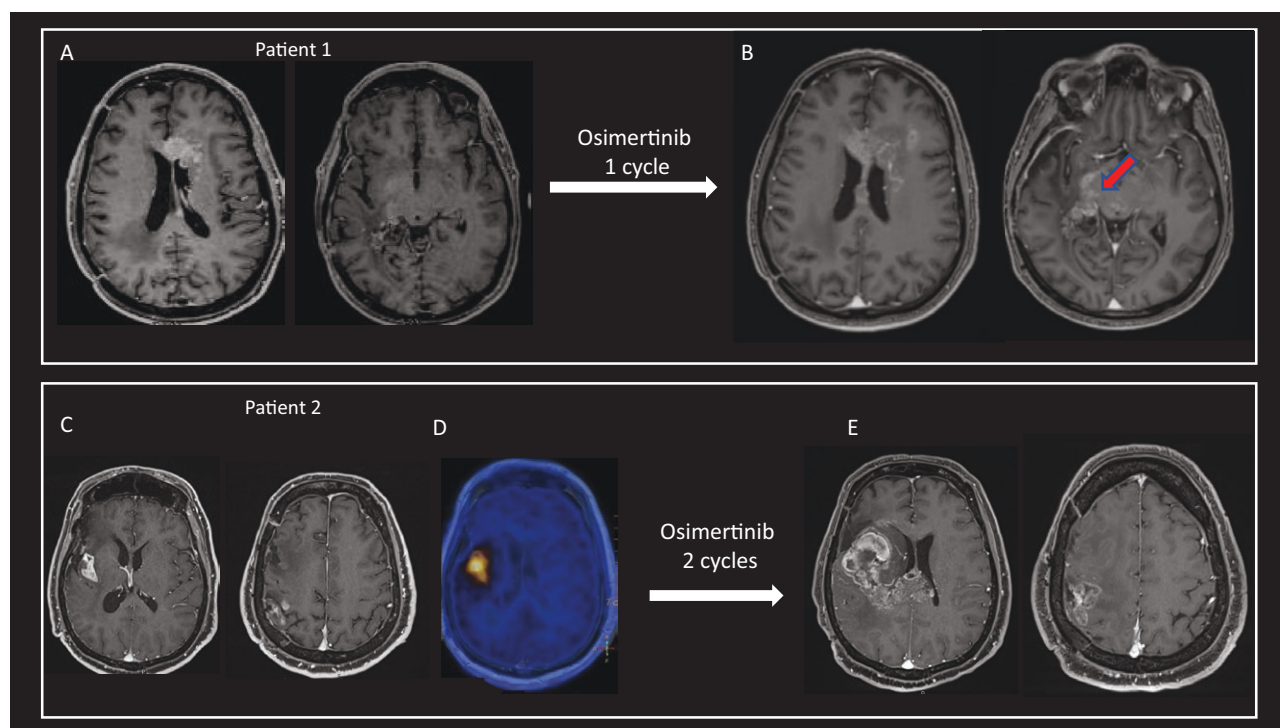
Targeted inhibition of EGFR pathway in 2 patients with recurrent GBM. Patient 1 showed third recurrence (A) of a GBM IDH wt with *EGFR* amplification after surgery, radiotherapy with temozolomide, second line and third line of chemotherapy, and gamma knife focal treatment on a further sub-ependymal cerebellar nodule (not shown). He started target anti-EGFR therapy with Osimertinib. Unfortunately, one month later he clinically deteriorated and MR imaging (B) showed significant progression of callosal and mesencephalic location (red arrow). Patient 2, developed contrast-enhancing recurrence of a GBM IDH wild type with *EGFR* mutation (c.2156G > A, p.G719D, allelic frequency 25.06%) after surgery, and first-line treatment with radiotherapy and temozolomide (C). PET Tyr imaging showed a high increase of SuvMax in the target contrast-enhancing tumor (Suvmax 6.2) (D). Based on the specific mutation of the *EGFR* genes, included in the repertoire of targetable mutation with third-generation anti-EGFR inhibitors, he was treated with Osimertinib as a second-line treatment. After 2 cycles, he showed clinical and radiological PD with multifocal progression of the tumor (E). IDHwt, IDH wild type; MR, magnetic resonance imaging; PET, positron emission tomography; PD, progressive disease; Tyr, tyrosine.
